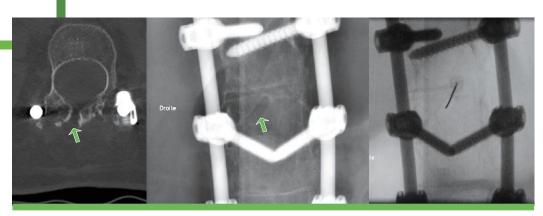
Pre-lumbar puncture X-ray and lumbar puncture.
